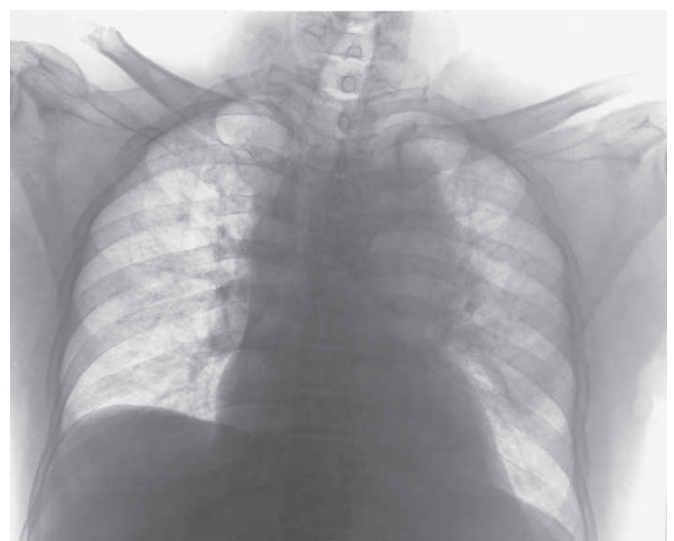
Chest radiograph showing mediastinal widening in a patient with aortic injury. Patient was hemodynamically stable and underwent endovascular stent graft
